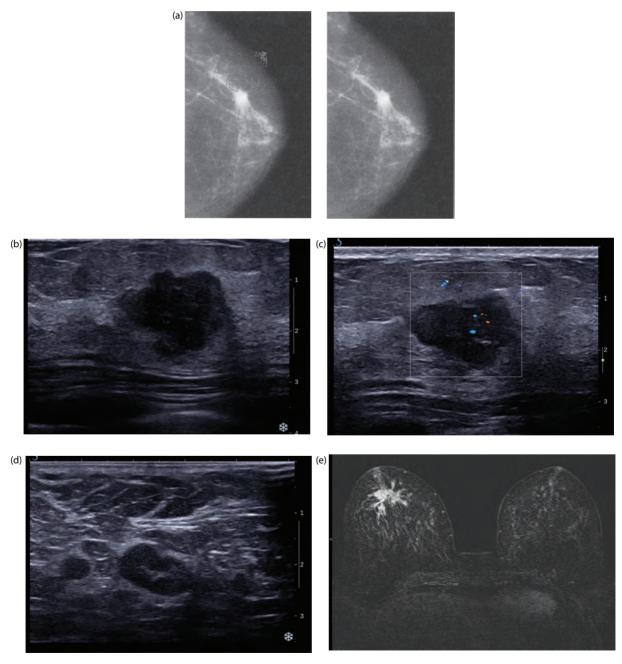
Images of breast cancer: (a) mammograms of a screen-detected breast cancer showing a spiculated mass. (b) Ultrasound image showing an ill-defined, inhomogeneous, irregular mass. (c) Colour Doppler image of a breast cancer showing central neovascularity. (d) Ultrasound of the axilla showing a node with a thickened cortex due to axillary metastasis. (e) MRI of invasive cancer.
